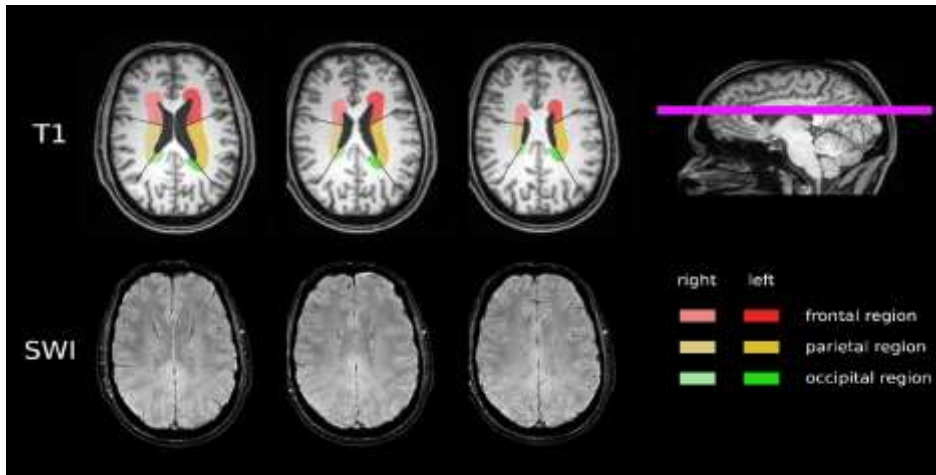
Visual assessment for DMV appearance on SWI, based on Zhang et al. The protocol was tailored for SWI sequences with a 3 mm thickness. Three continuous periventricular sections were chosen, as indicated by the pink bar on the sagittal section on the right side of the panel. Each section was subdivided into six regions (depicted in different colours), encompassing frontal, parietal, and occipital areas on both sides. A score ranging from 0 (indicating a completely normal and homogenous appearance of DMV) to 3 (indicating highly disorganized and nearly invisible DMV) is assigned to each region. The sum of the scores from all regions yields the final score (ranging from 0 to 18). The upper row of T1-weighted images shows the anatomical details of the selected regions, while the lower row of SWI sections demonstrates the appearance of the DMV for visual evaluation.
